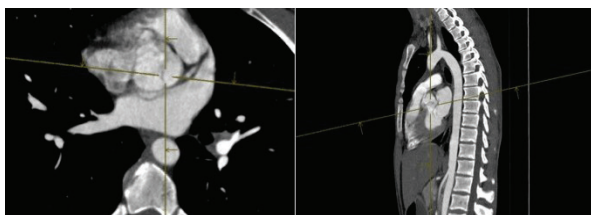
Computed tomography angiography of aorta.
